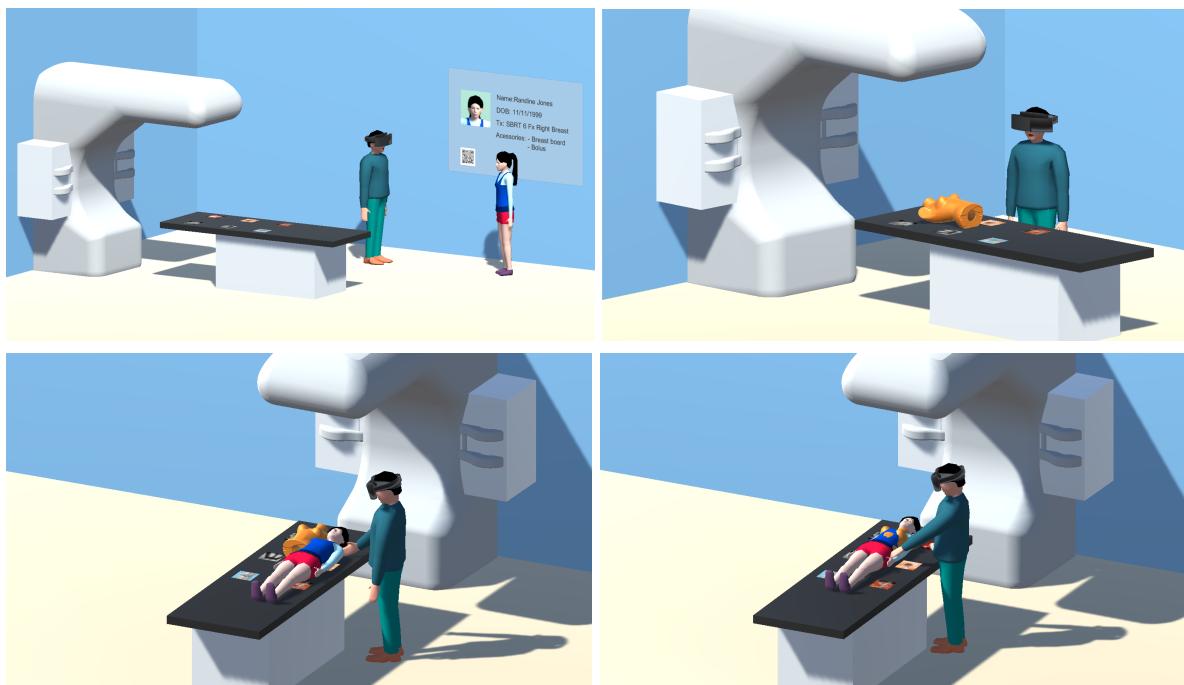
In Unity, the image targets and 3D CT hologram being placed with reference to each other.
